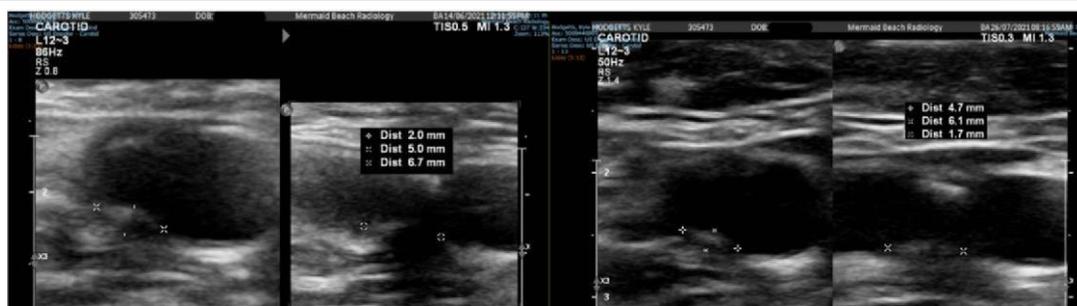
Carotid ultrasound performed pre -trial and after completion of phase III which shows improvement of plaque size from (6.7x5.0x2.0mm) to (6.1x4.7x1.7mm).
